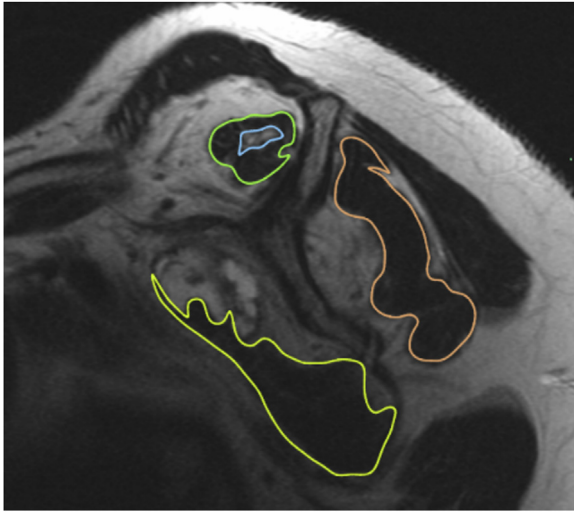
Select sagittal magnetic resonance imaging scan of a rotator cuff showing partial fatty infiltration and muscular atrophy. Surface area with individual muscle measurements were calculated automatically via OsiriX software. Areas of acute fatty infiltration were subtracted from total volume measurements. The location of the image was chosen as the most lateral point in which the scapular spine is connected to the scapular body. Cuff muscle outlines were then traced while excluding infiltration areas. Infraspinatus and teres minor areas were merged together for quantification.
